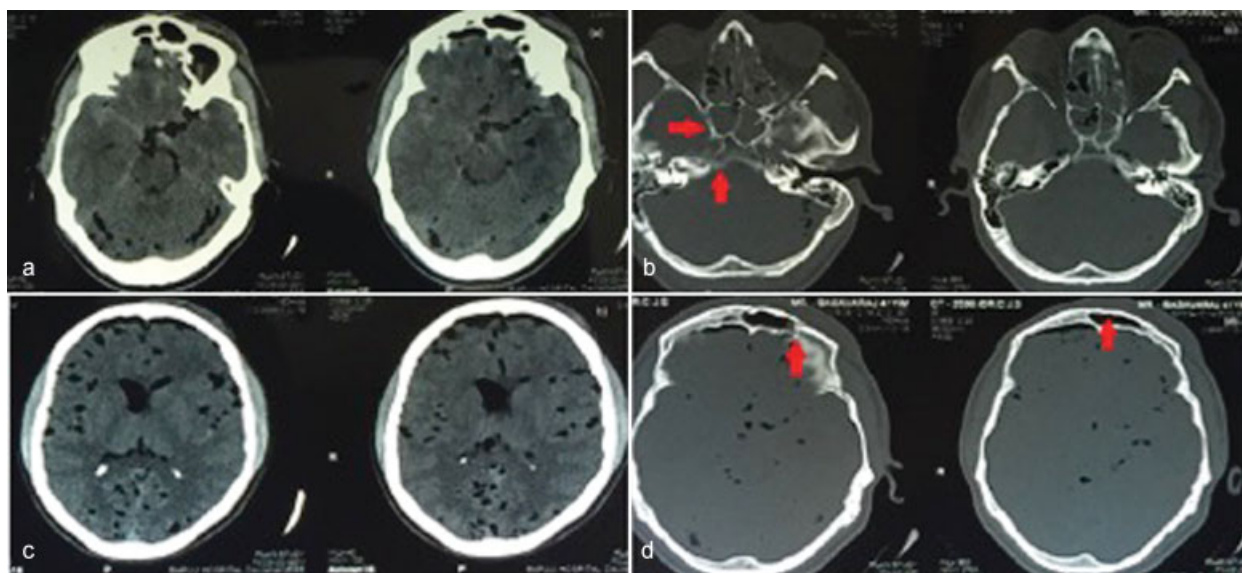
Plain CT scan, axial cuts, showing pneumo in the basal cisterns with subarachnoid hemorrhage (a, c) with planum sphenoidal and frontal sinus fracture depicted in the bone window (b, d).
